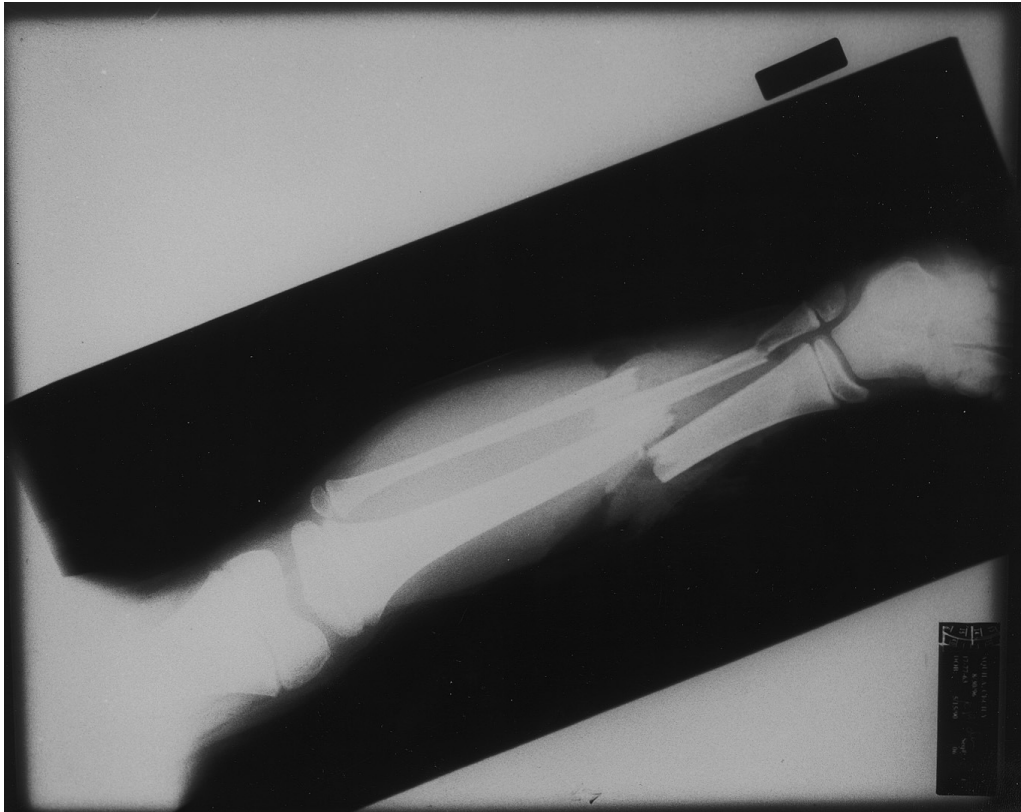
Radiograph showing fractures resulting from a bending mechanism.
